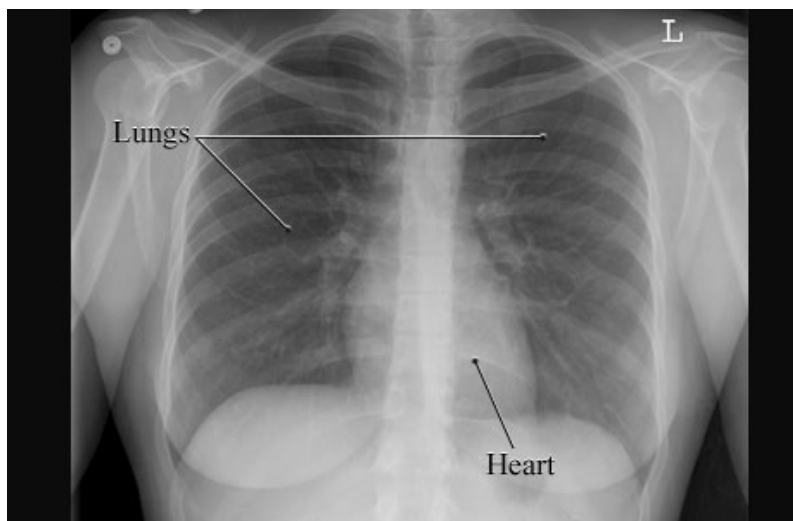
Chest X-Ray of Healthy Lungs (MyHealth.Alberta.ca, 2018).
